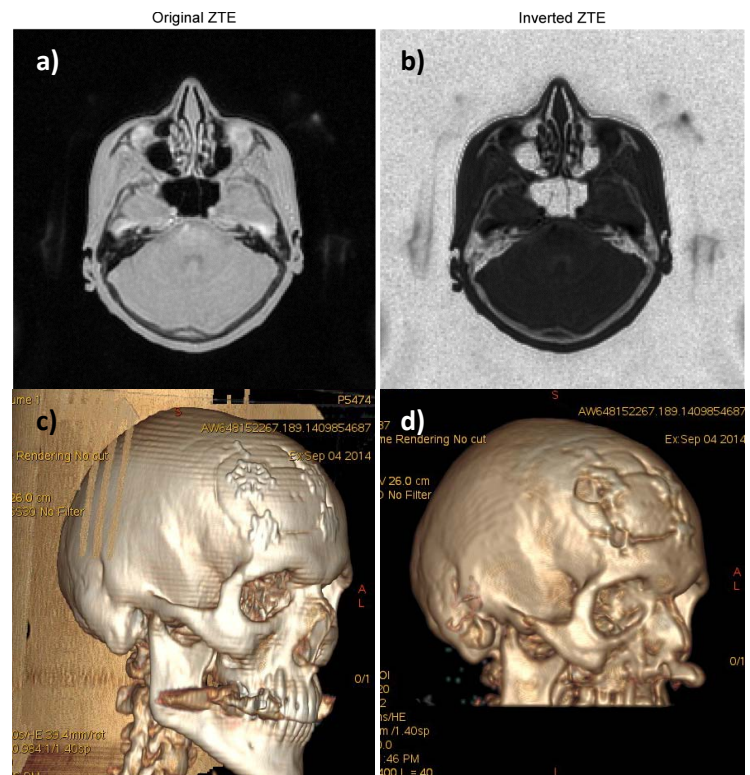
Axial views of a typical post-operative ZTE volume (a) before and (b) after intensity rescaling. Volume rendered views of the reference CT dataset (c) and ZTE-based bone mask (d).
